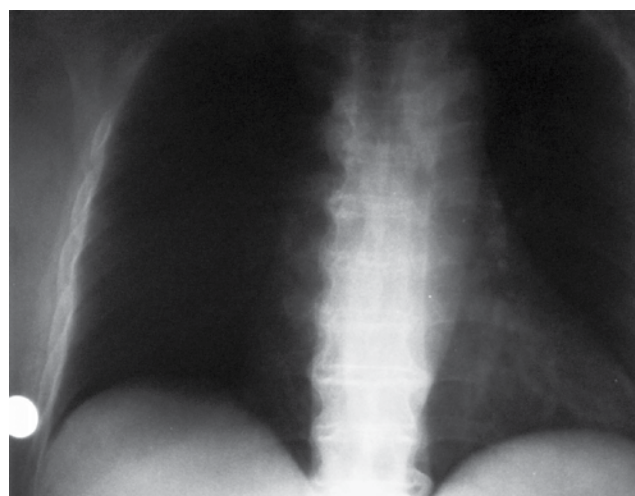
A) Anteroposterior radiograph of the thoracic spine; shows flowing calcification and ossification along the anterolateral aspect of the contiguous vertebral bodies
